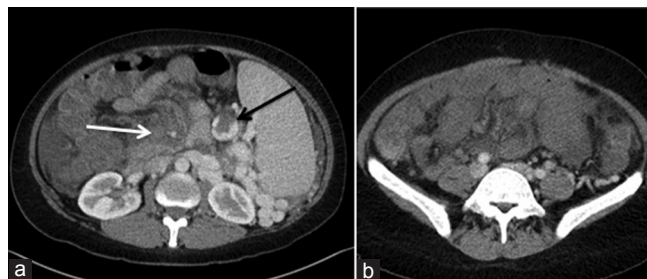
Axial computed tomography scan shows (a) acute thrombosis of the superior mesenteric vein (white arrow) and splenic vein (black arrow) and (b) lack of enhancement of the small bowel associated with extensive wall edema
